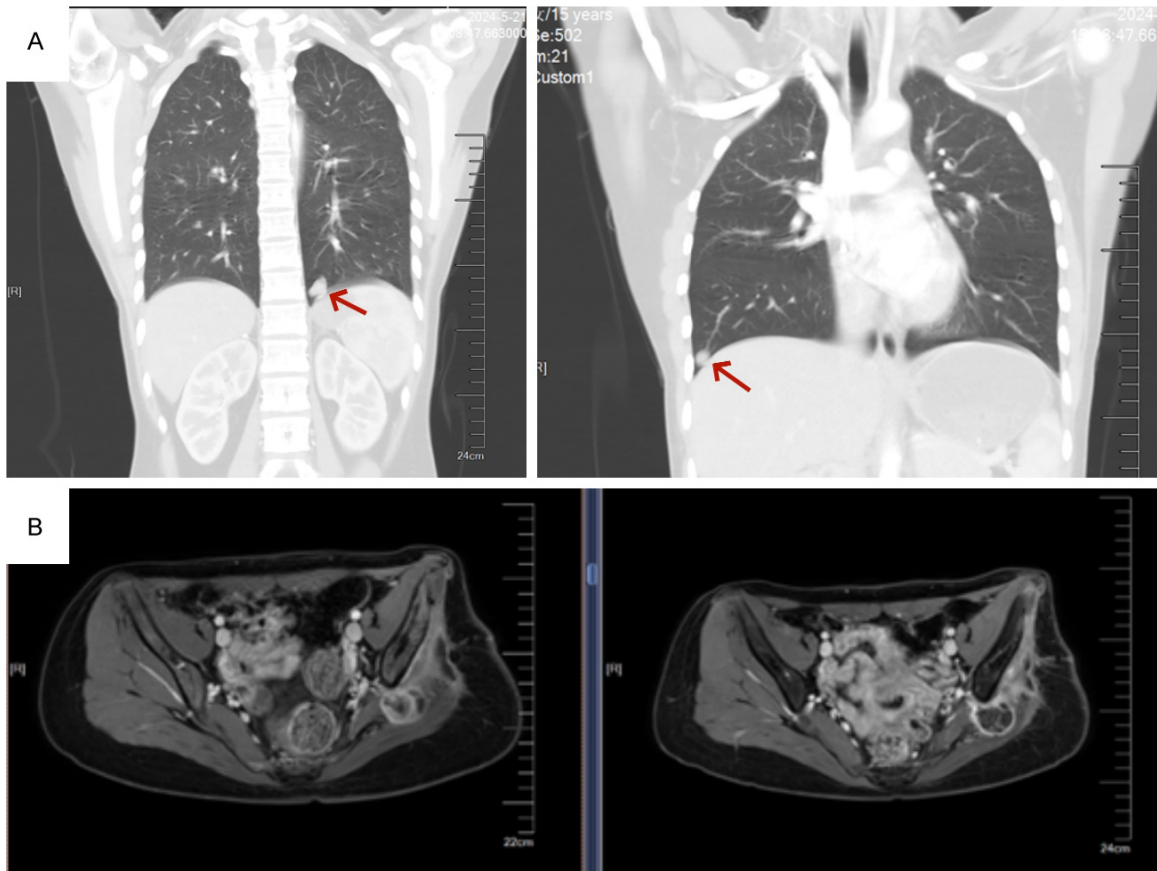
Follow-up examination images. A. A chest CT scan performed on May 21st revealed multiple metastatic tumors, indicated with red arrows, in both lungs. Some tumors showed shrinkage, while others demonstrated an increase in size compared to previous scans. B. An MRI indicated that the size of the tumor remains essentially the same as before, but the enhancement has been reduced. The two panels display different layers of the tumor as observed on MRI scans.
